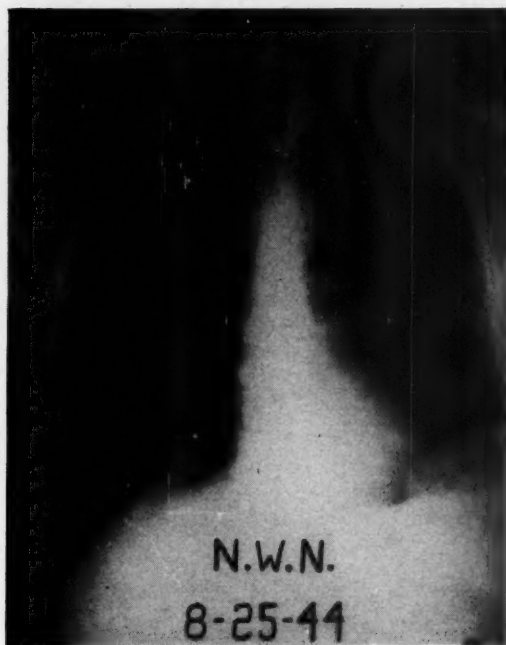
Circumscribed density in left costophrenic angle found on survey x-ray film when changing jobs. Exploration revealed diaphragmatic hernia produced by bullet wound 15 years previously.
